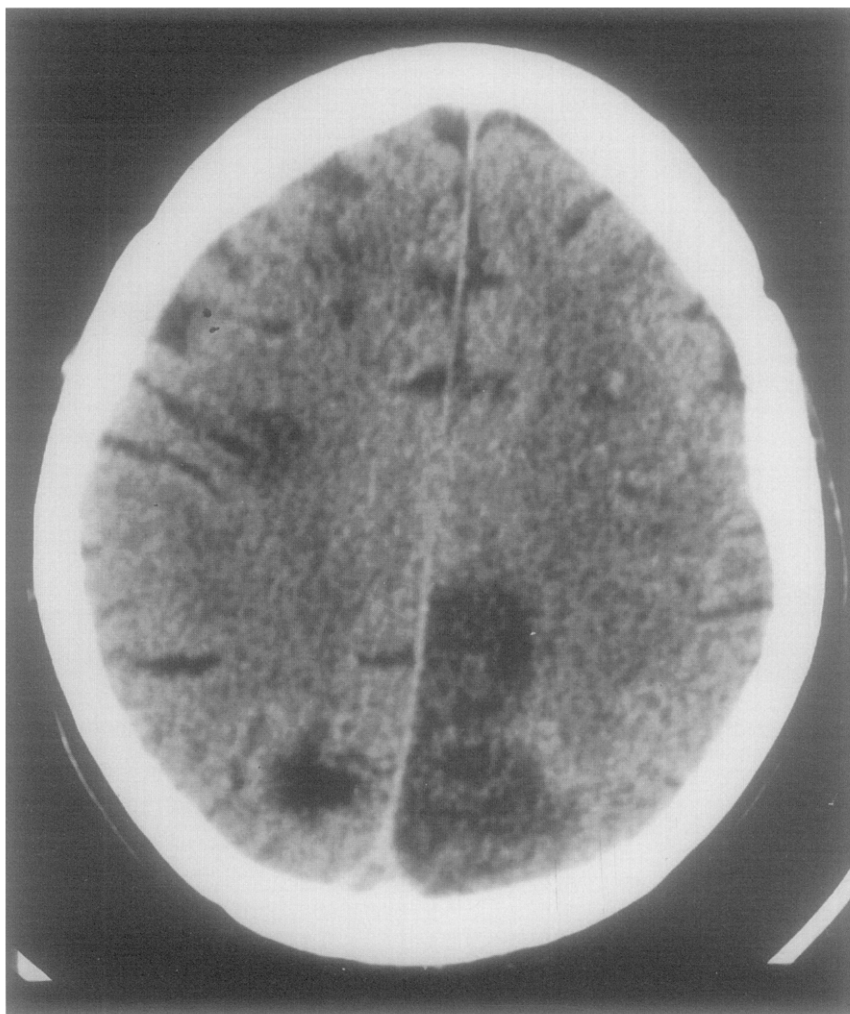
CT scan 3 days after surgery demonstrates multifocal infarcts; however, there is no evidence of infarction in distribution of ACA, and there is no evidence of intracranial hemorrhage.
